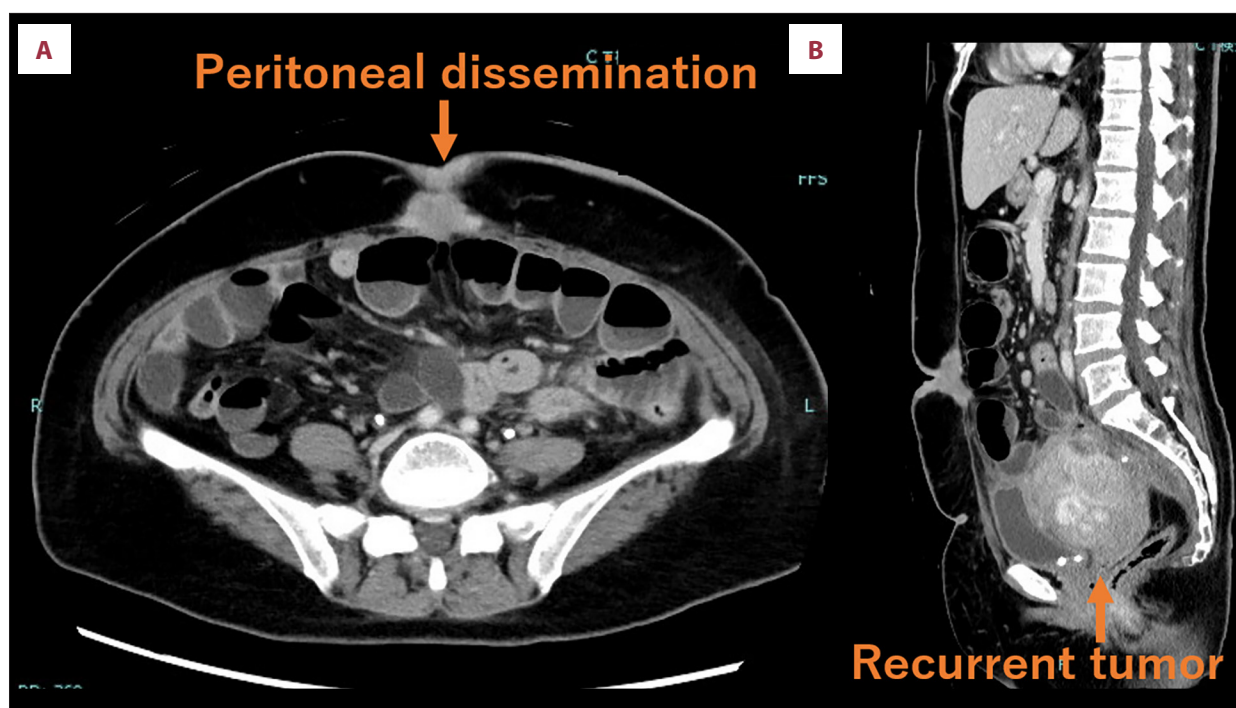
Transverse (A) and sagittal (B) computed tomography images of the abdomen after surgical resection for sigmoid colon cancer, demonstrating peritoneal metastasis around the umbilicus (A) and local recurrence in the sacral region (B).
